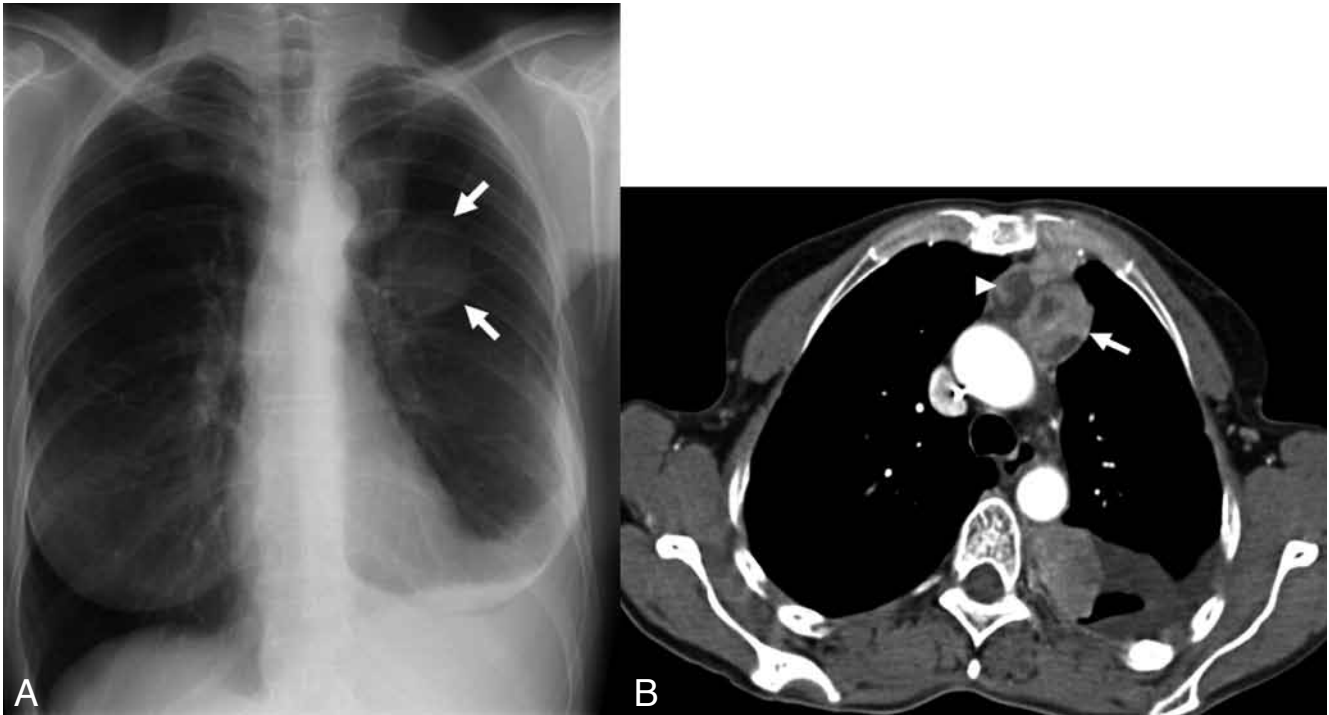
Thymic carcinoma. A. Thymic carcinoma in a 50-year-old woman with weight loss and coughing at night. PA chest radiograph shows a smooth, sharply marginated left mediastinal mass (arrows). B. CT showed a mass in the left anterior mediastinum with enhancement following contrast infusion (arrow). The mass contained central necrotic and cystic areas (arrowhead).
